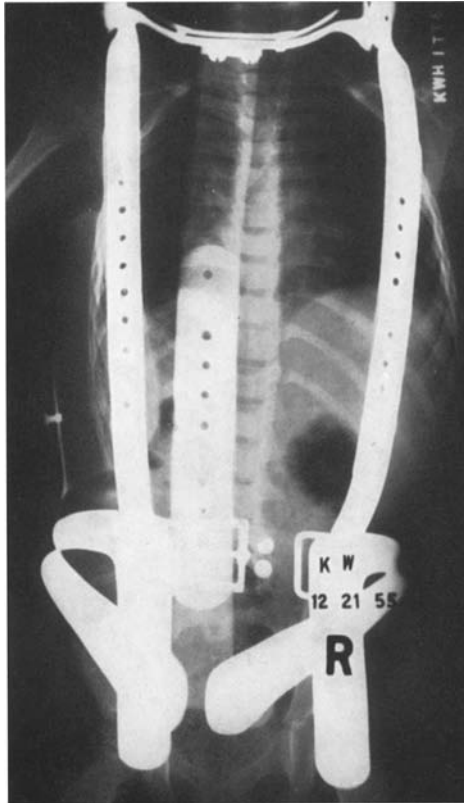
K. W. An x-ray taken through the brace shows overcorrection of the left convex curve by distraction and lateral pressure. The pad can be seen on the left
